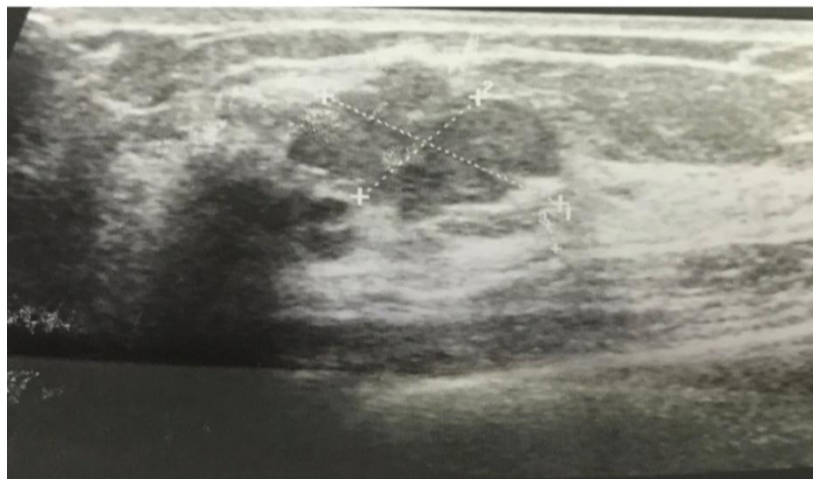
Sonography showed non-vascular homogeneous mass, very hypoechoic with microlobulated borders at right upper outer quadrant that measures 24×11.5 mm.
